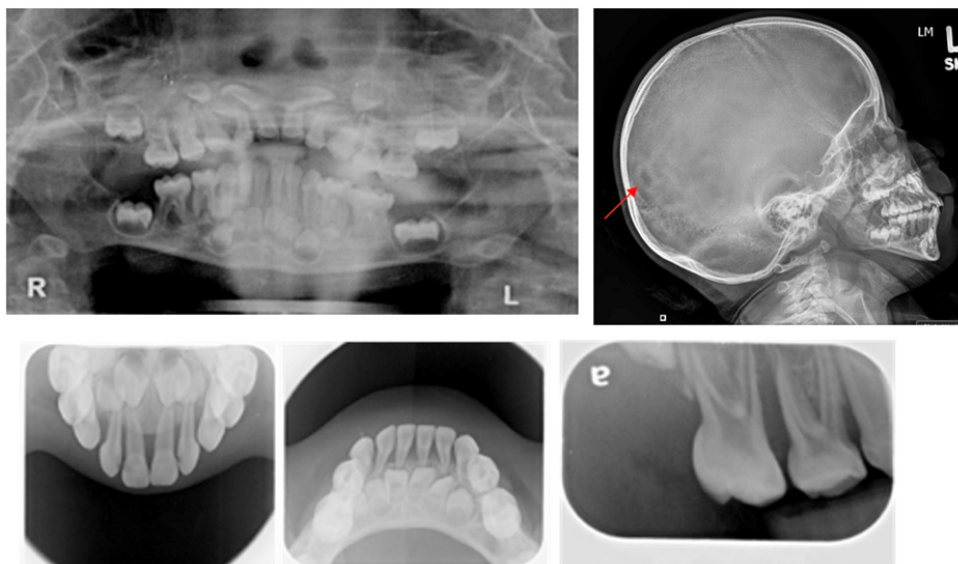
Dental, lateral cephalometric and skull radiographs were taken when patient was 3 years old (1/30/2015). (i) Horizontal and angular bone loss on primary teeth. (ii) Arrow indicates an osteolytic lesion of the skull.
